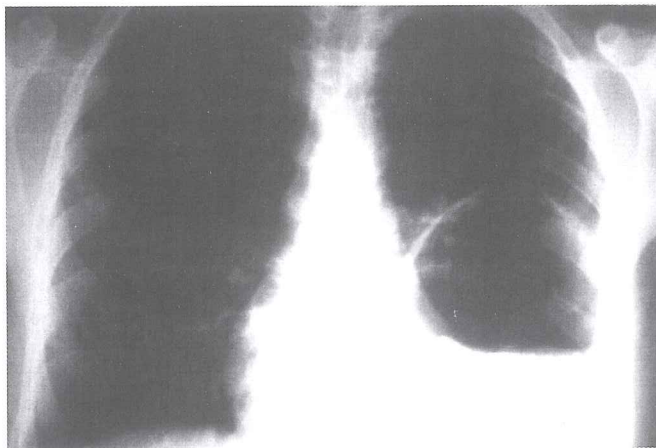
Chest X-ray showing a persistent cavity determined 3 months after cystostomy + capitonnage.
